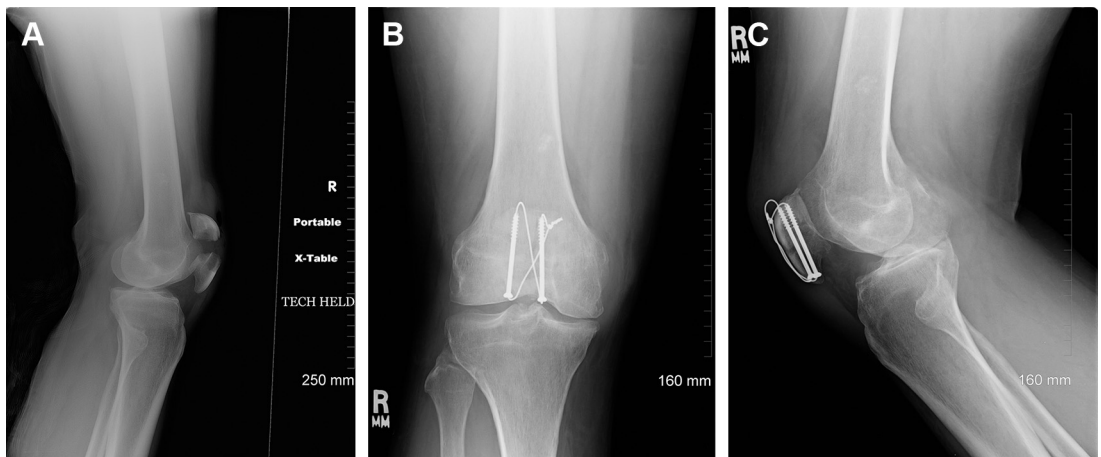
(A) Lateral radiograph of open transverse fracture of the patella with significant displacement. (B, C) Anteroposterior and lateral radiographs following fixation with 4.0-mm cannulated lag screws and tension band.
